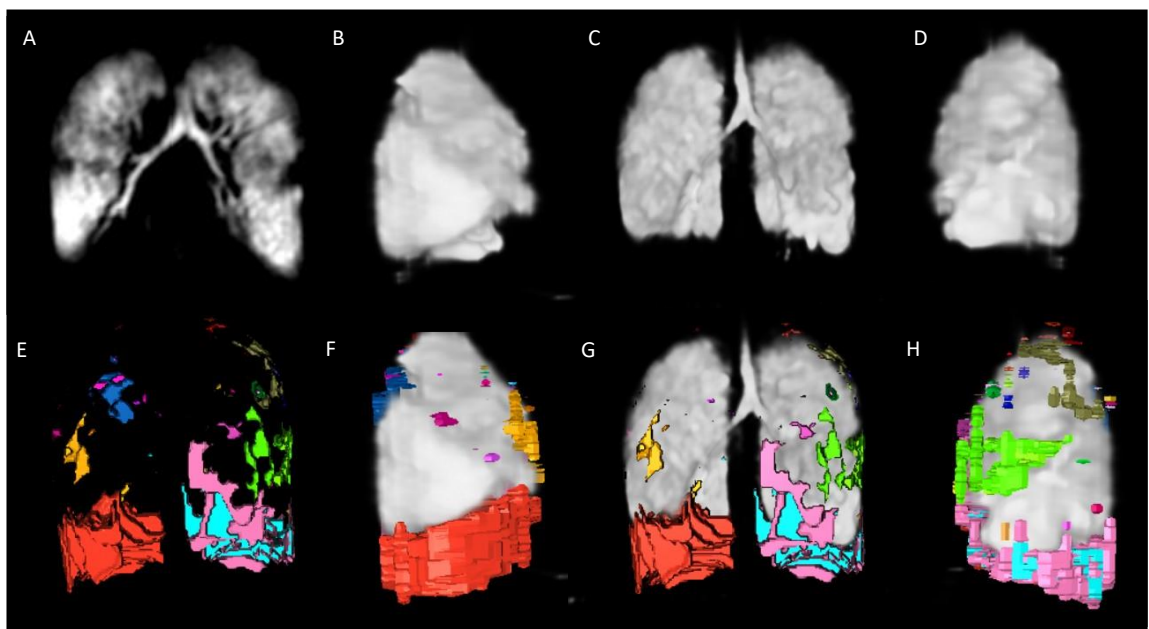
3D visualisation of ^{129}Xe MRI images of Case 16 produced using Simpleware Scan IP (Synopsis, Inc, 2022) A depicts a 2D coronal central slice. B, C and D depict 3D anatomical views of ventilation, looking anteriorly (C), at the right lung (B), left lung (D). E shows the ventilation defect mask, with each colour showing a contiguous defect. F-H show the ventilation defect mask applied over the ventilation image looking anteriorly (F), at the right lung (G), left lung (H).
